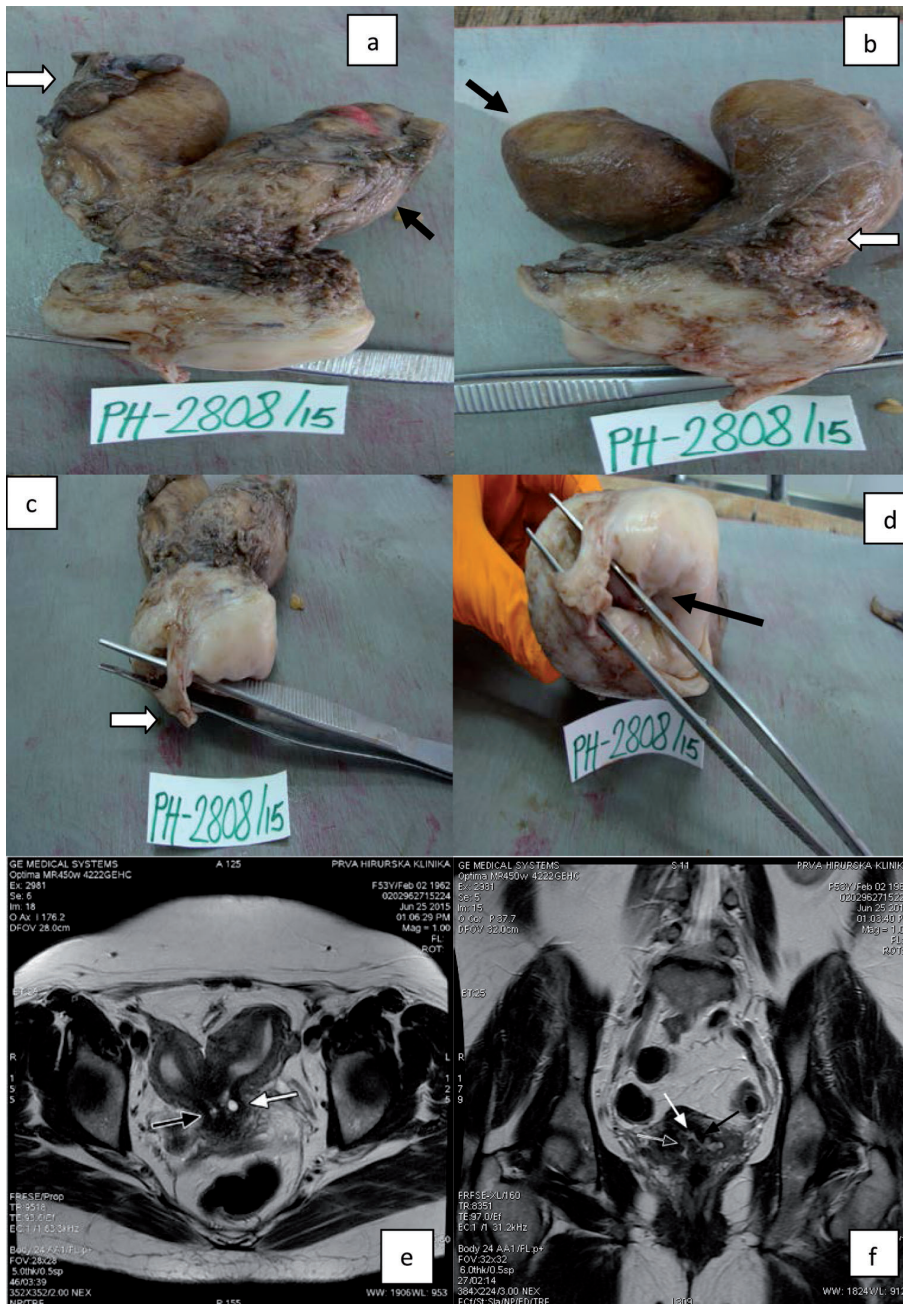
Operative findings of the extracted uterus and preoperative MRI. a) anterior side (black arrow—right uterus; white arrow—left uterus); b) posterior side (black arrow—right uterus; white arrow: left uterus); c) cervical septum (white arrow); d) common cervical os (black arrow); e) axial T2-weighted MRI (black arrow—right cervical canal; white arrow—left cervical canal); f) coronal T2-weighted MRI (black arrow—left cervical canal; white arrow—common external cervical os; opened arrow—right cervical canal).
